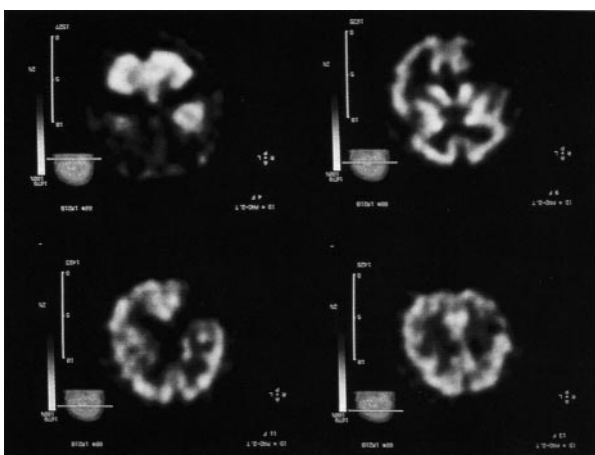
Another outstanding SPECT image from 1988, by Kimura of Osaka University Medical School, used technetium-99m HMPAO.
